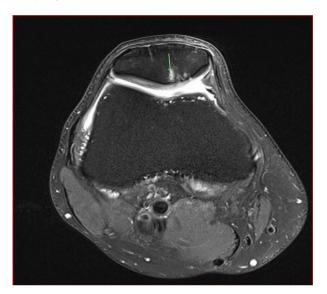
Fat-Suppressed T2 MRI, Nine months post-treatment, demonstrating stable subchondral bone marrow oedema and cysts
